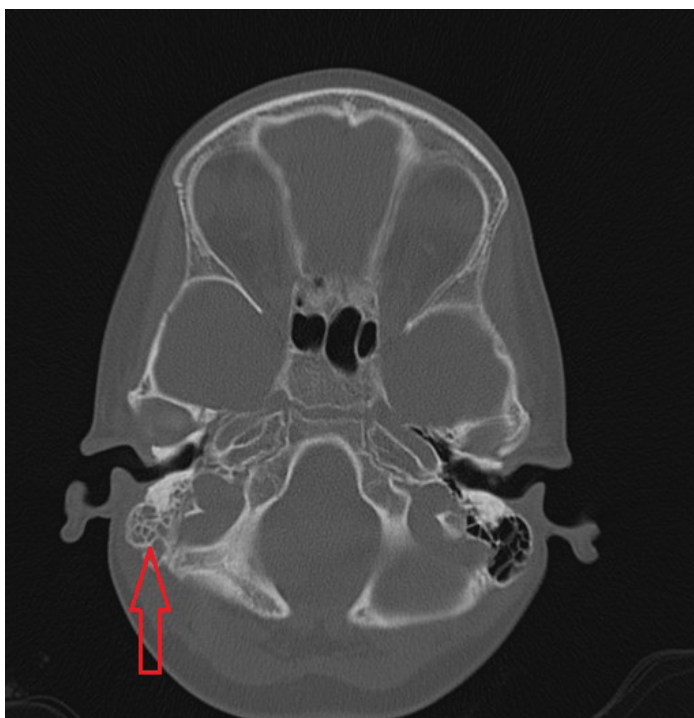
A CT scan without intravenous contrast identified acute otitis media on the right side, accompanied by sclerosis, opacity of mastoid cells, and thickening of the tympanic membrane (highlighted by a red arrow).
